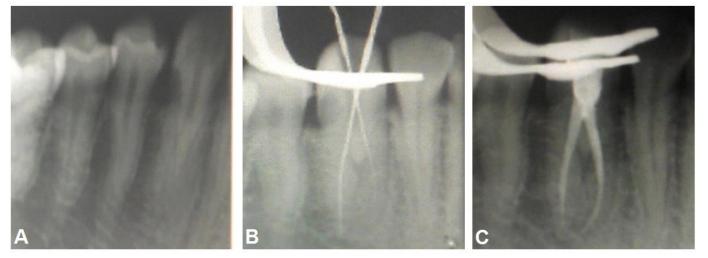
Radiographs of tooth 33. A) Preoperative radiograph, B) Working length radiograph, and C) Post obturation radiograph
